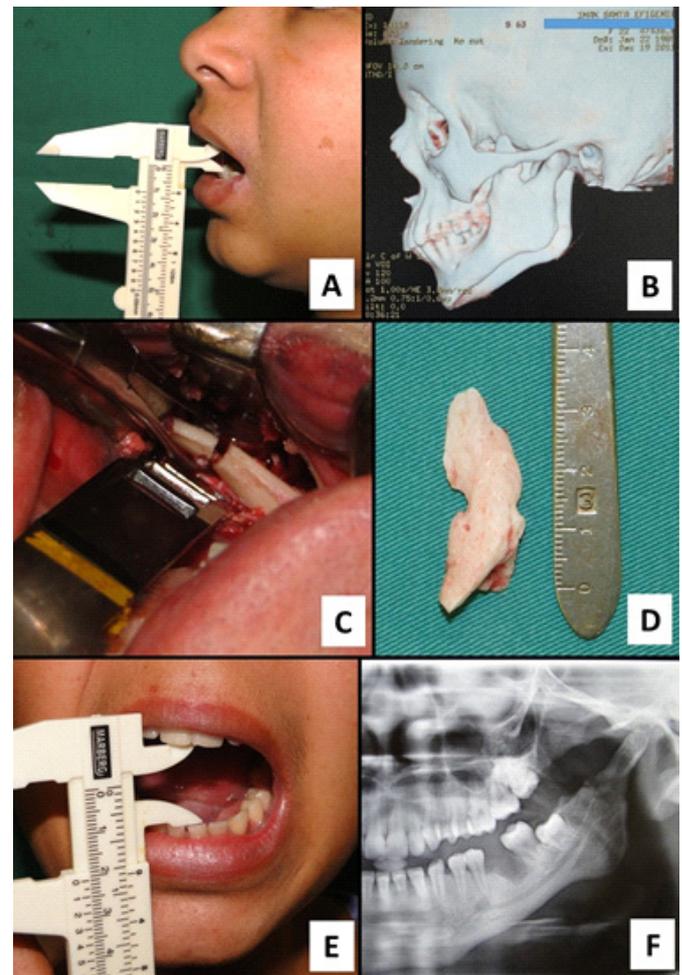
A) Preoperative mouth opening. B) Computed tomography in 3D reconstruction demonstrating enlargement of coronoid process of the mandible. C) Intraoral access and coronoid process osteotomy. D) Removed surgical part. E) Mouth opening on the 10th postoperative day. F) Postoperative panoramic radiography.
